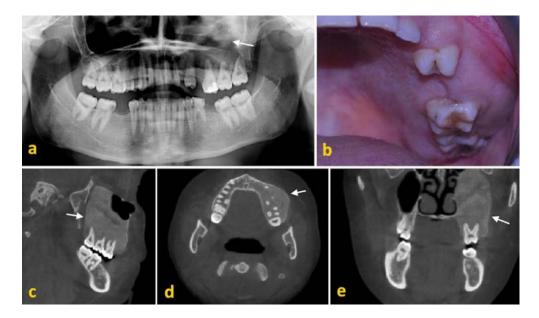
(a) The panoramic radiography of FD. (b) Intraoral view of patient showed buccopalatal expansion in the left posterior maxillary region. The CBCT images of FD: (c) sagittal, (d) axial, and (e) coronal section showed a sizeable ground-glass lesion filling the maxillary sinus at the level of the left molar with buccopalatinal expansion.
